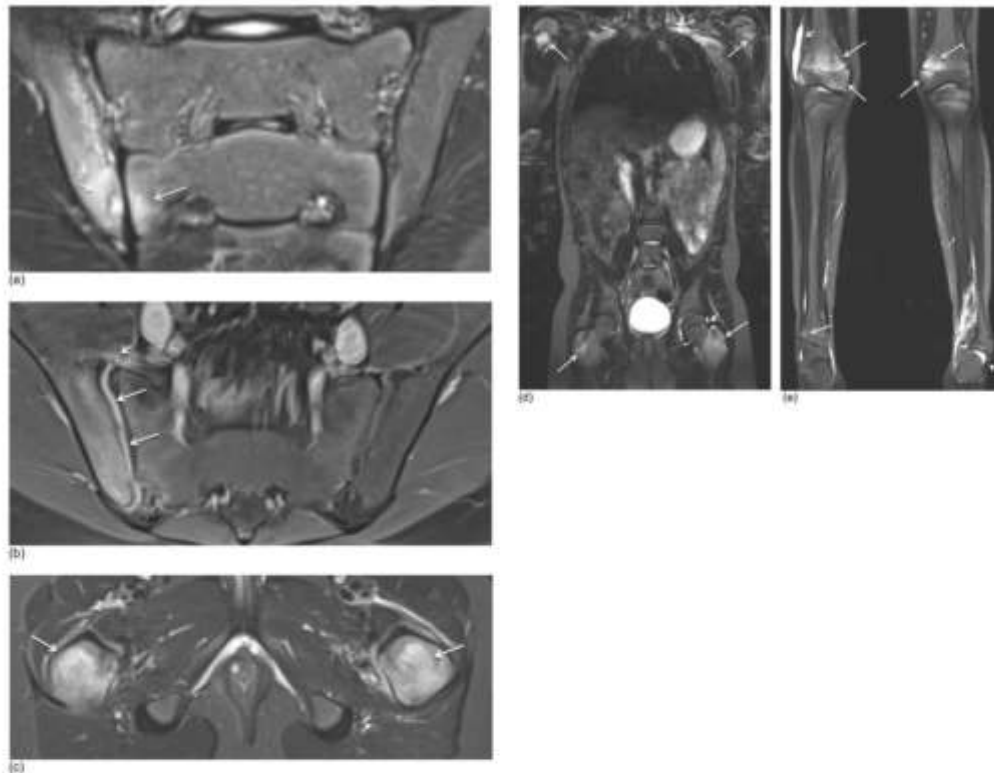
Sacroiliitis (active and structural lesions) and CRMO in a 13-year-old boy. (a) Semicoronal STIR MR image shows an active erosion with extensive BME at the iliac side of the right SI joint (short arrow) and moderate BME at the sacral side of the right SI joint (arrow). (b) Axial fat saturated T1-weighted MR image after IV Gd shows synovitis with extensive synovial enhancement (arrows) and capsulitis (short arrow). (c) Axial STIR MR image shows diffuse BME in the proximal femur on both sides (arrows). (d-e) Whole body MRJ was performed and confirmed the diagnosis of CRMO with arthritis of multiple joints (short arrow) and diffuse epiphyseal and metaphyseal BME (arrows) on coronal STIR MR images.
